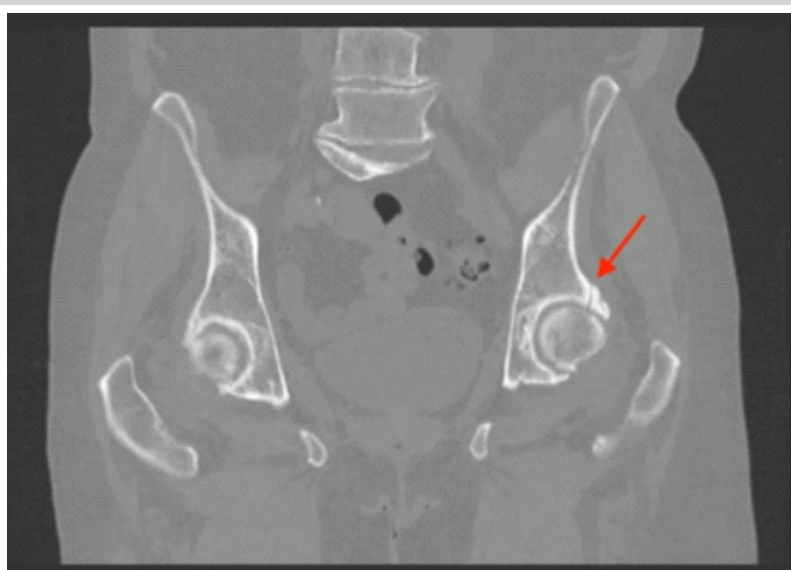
Coronal computed tomography of the pelvis showing left posterosuperior acetabular fracture. Computed tomography of the pelvis without contrast (March 7, 2024). Coronal reconstructions demonstrate a linear fracture of the posterosuperior aspect of the left acetabulum without significant displacement. Surrounding sclerosis is noted. Moderate bilateral hip osteoarthritis is visible.
